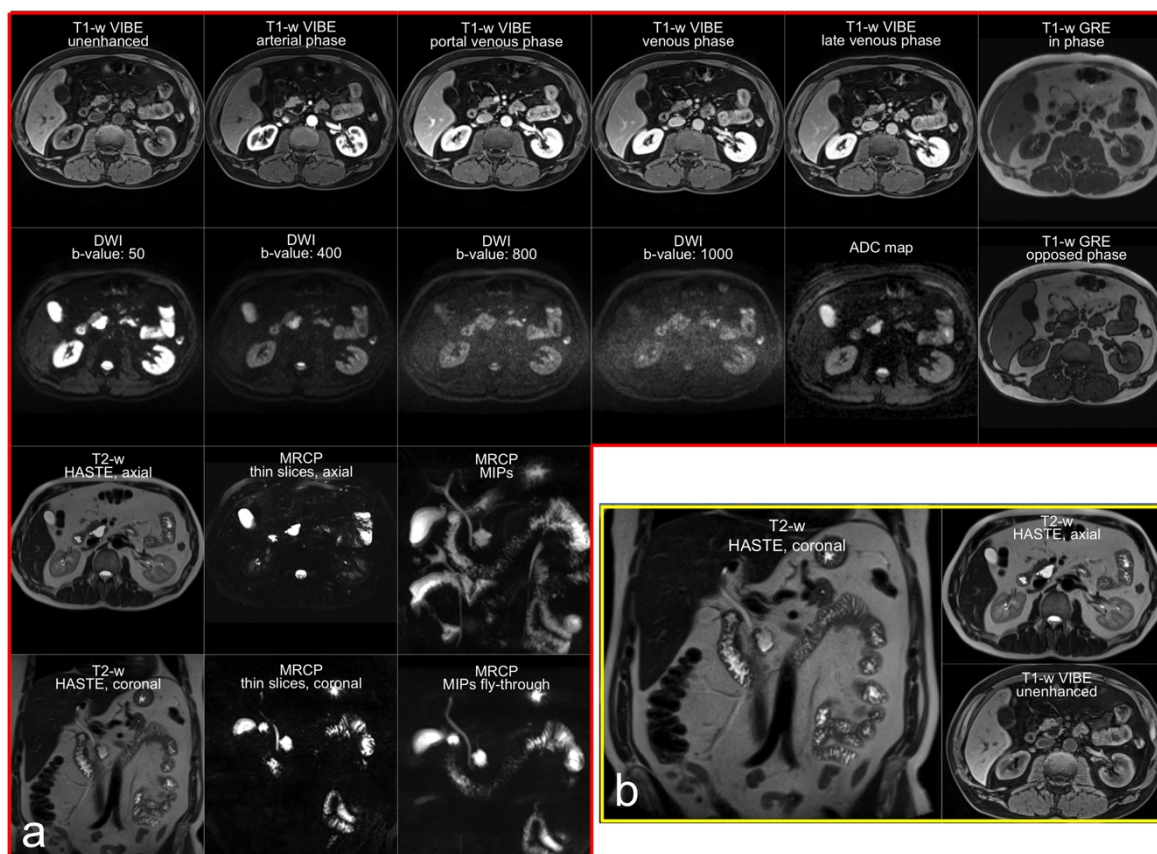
MRI imaging datasets (a, b) derived from the same examination performed in a 65-year-old patient under follow-up for a pancreatic cystic neoplasm in the uncinata process. The comprehensive protocol imaging data set is displayed with red edges (a); the short protocol data set with yellow edges (b). Reprinted with permission from Springer Nature.
